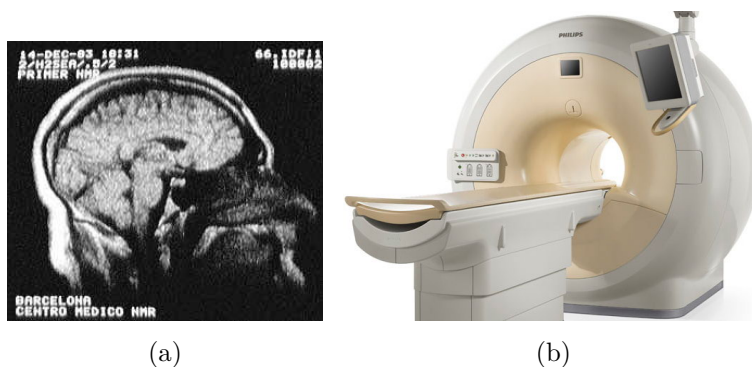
(a) First Magnetic Resonance images of the brain, acquired in Spain on December 14, 1983. Spin- Echo T_1 . Centre Diagnòstic Pedralbes. Barcelona. (Source: [Gili 2007]). (b) MRI system Philips Achieva 1.5T A-series. (Source: Philip website 2012, http://www.healthcare.philips.com/us_en/).
